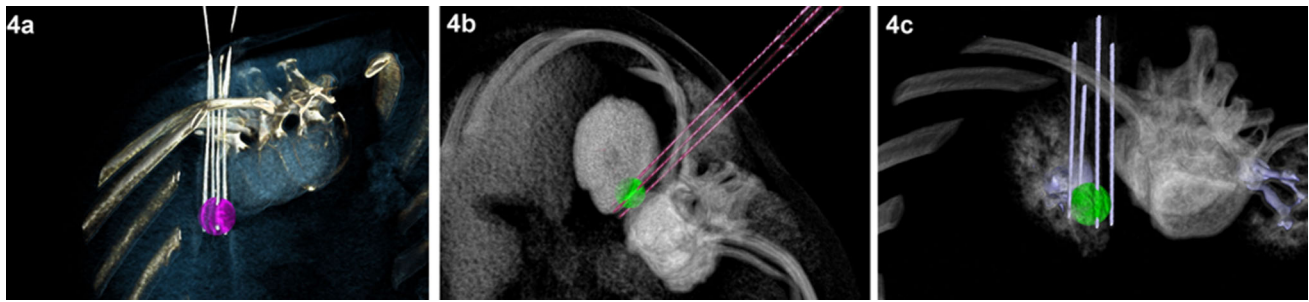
3D-CT-reconstruction of the IRE electrode placing (case 1, A; case 2, B; case 3, C)
